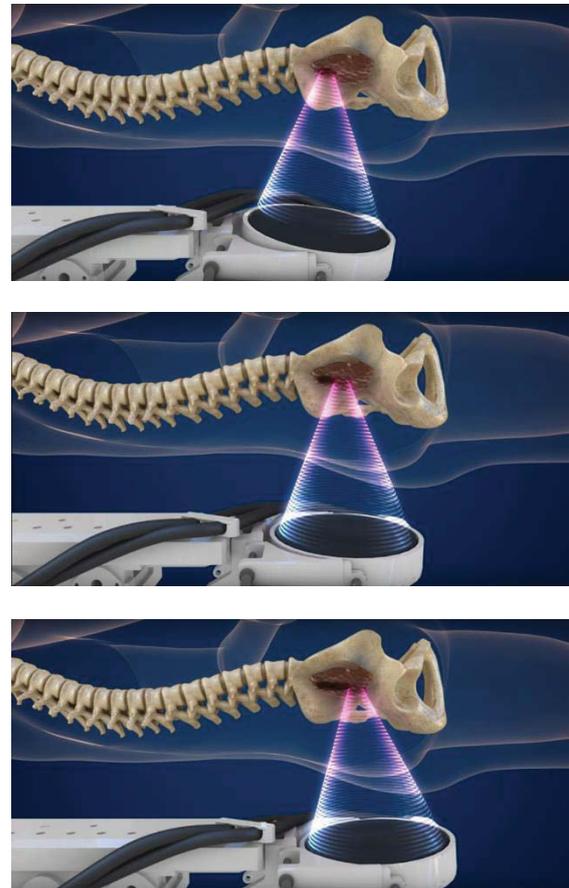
Ultrasound treating tumour inside the MR scanner [30]
